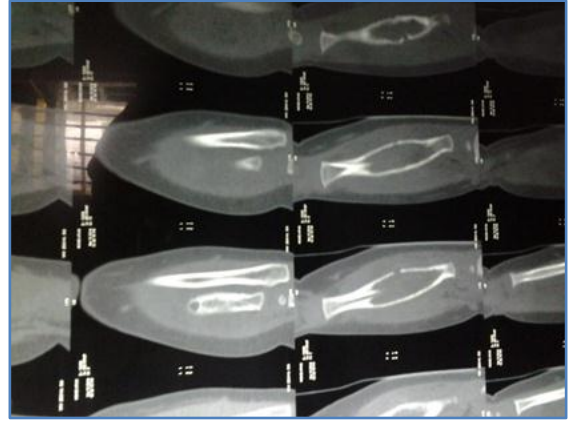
CT scan of the forearm revealed destruction of the cortex of the diaphyseal region of the radius with an associated periosteal reaction
